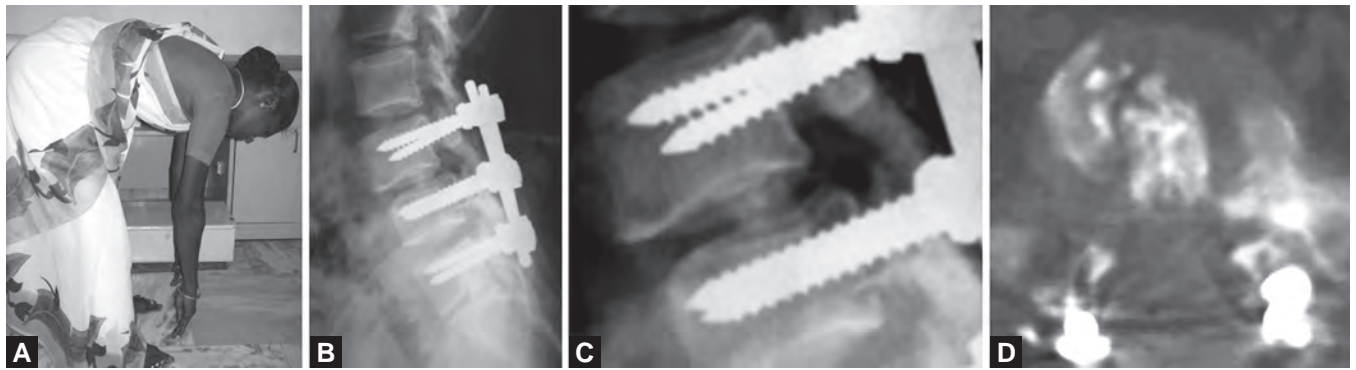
Reduction of grade 1 DSO with pedicle screws in (pre- and post-operative radiographs)
